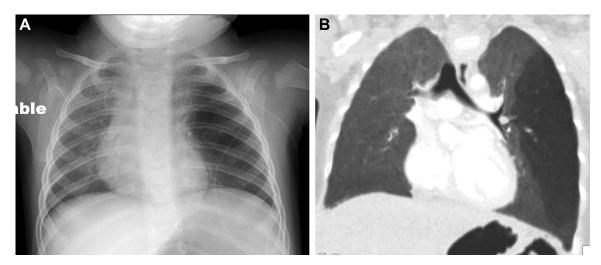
A, Anterior-posterior chest radiograph in a 7-mo-old boy with a history of congenital lobar overinflation showing hyperexpansion and hyperlucency of the left hemithorax. B, Coronal minimum intensity projection image on lung windows in the same patient showing relatively diffuse air trapping in the left upper lobe and lingula with sparing of the apex and left lower lobe and normal central airway anatomy.
